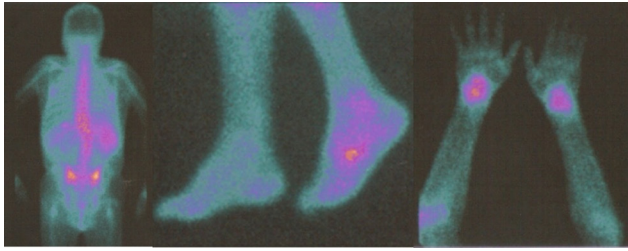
Gallium scintigraphy: pathological osteoarticular hyperfixation with involvement of both carpi, sacroiliac joints and left tarsus.
